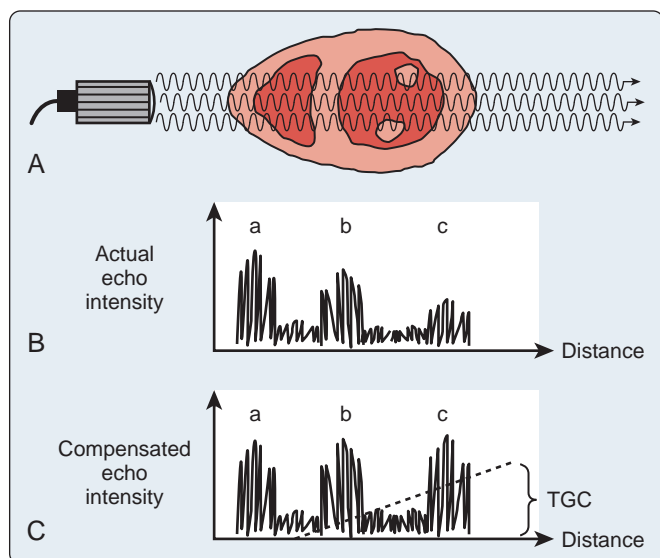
(A) As an ultrasound beam is aimed across the heart, specular echoes are reflected at the right ventricular wall (a), the septum (b), and the left ventricular wall (c). (B) The normal loss of echocardiographic strength is due to the decreasing intensity of the beam as it propagates through the heart. (C) Time-gain compensation (TGC) allows the intensity of the far-field signals to be increased selectively. (From Thys DM, Hillel Z. *How it works: basic concepts in echocardiography*. In: Bruijn NP, Clements F, eds. *Intraoperative Use of Echocardiography*. Philadelphia: JB Lippincott; 1991:255–318.)
